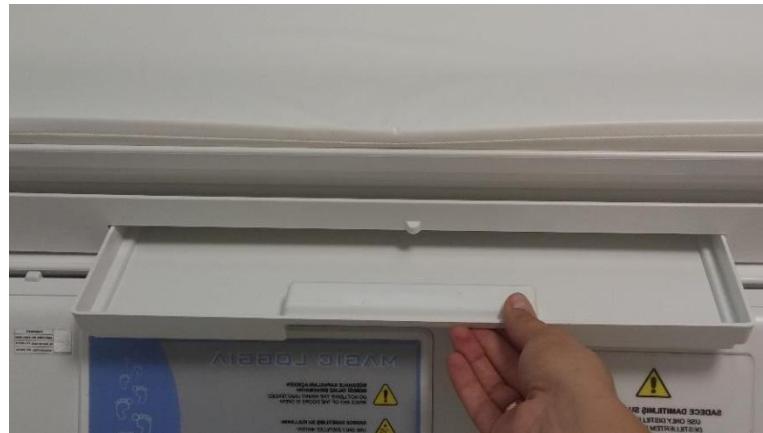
Disassembling the X-Ray Tray
